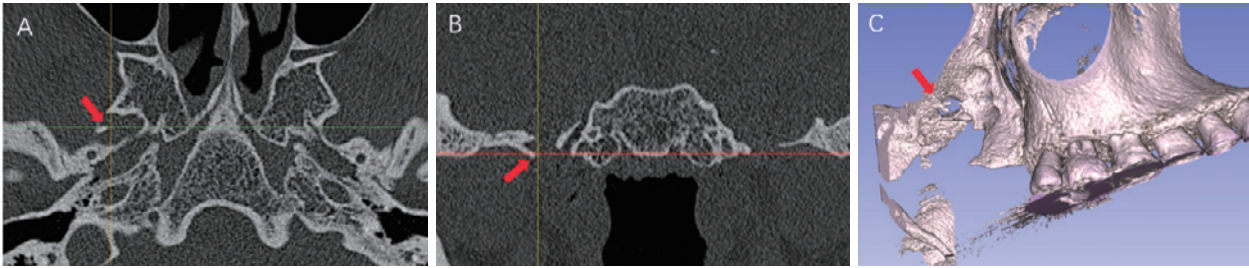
HRCT and 3D reconstruction of the right foramen ovale region: (A) and (B) HRCT of the skull base showed an abnormality in the right foramen ovale region (red arrow). (C) 3D reconstruction demonstrated an osteophyte just underneath the posterolateral edge of the foramen ovale (red arrow).
